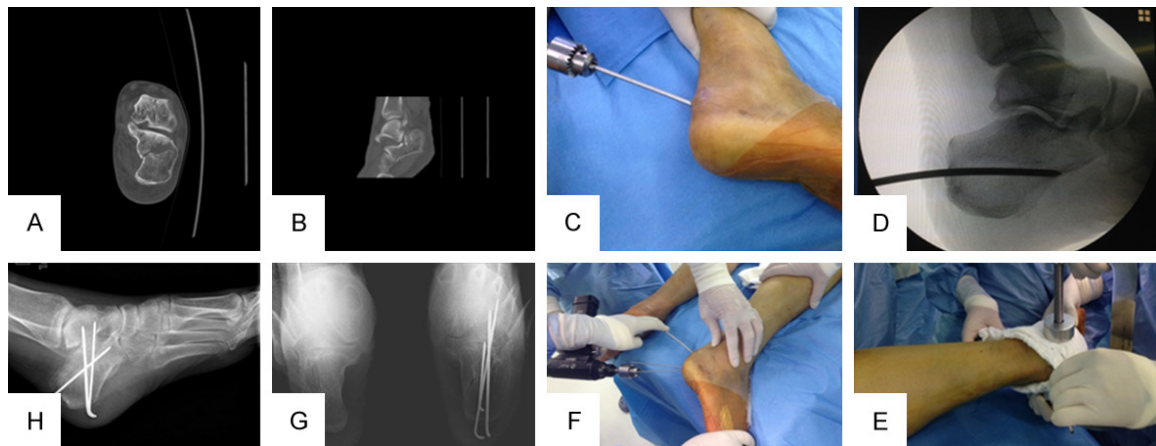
Percutaneous Steinmann pin reduction surgery. Preoperative X-ray showed the intra-articular calcaneal fractures (A, B); The Steinmann pin was driven to poke the collapsed articular surface (C). After satisfied positioning was obtained, the broken ends of fractured bone were poked (D) and the calcaneus was squeezed (E) to correct the calcaneal width. The width of calcaneus was corrected by driving into Kirschner wire (F); Postoperative X-ray showed that the calcaneal height, Böhler angle, and Gissane angle were significantly improved and the calcaneal width was recovered well (G, H).
